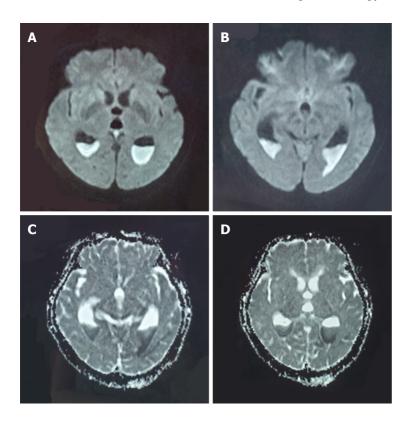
Head magnetic resonance imaging before admission. A and B: The fester-traditional cerebrospinal fluid level was seen inside the posterior horns of the bilateral lateral ventricles, and the fester diffuse weighted imaging showed a high signal; C and D: The fester showed a low signal on the apparent diffusion coefficient map.
